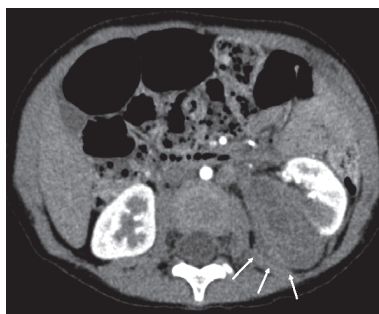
Computed tomography finding after chemotherapy The image reveals a reduced tumor size (white arrows).
